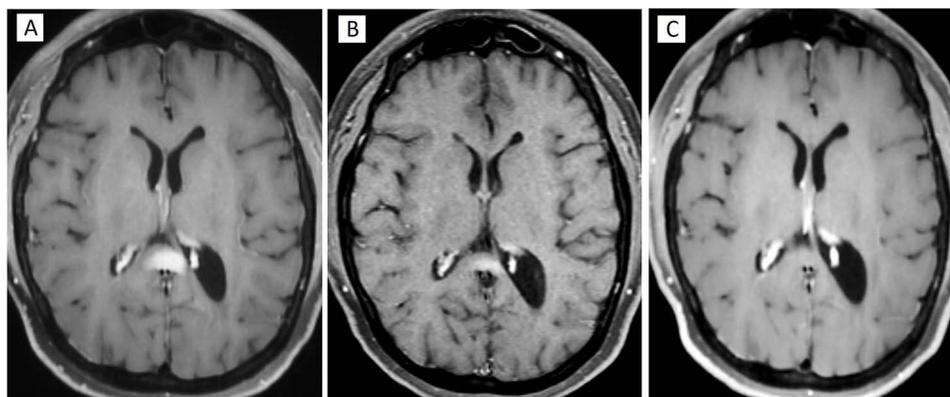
MRI Imaging Post-Treatment. (A and B) MRI after salvage therapy with near complete remission. (C) Repeat contrast enhanced MRI following day 100 work-up status post second ASCT shows complete remission.
